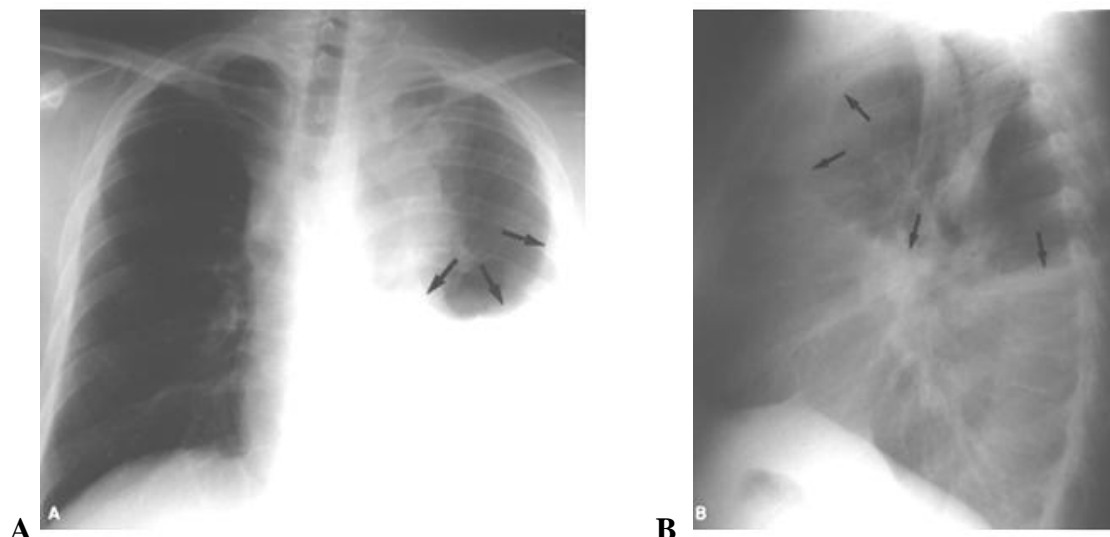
Right pleural effusion on frontal chest radiographs. (A) Posteroanterior and lateral (B) chest radiographs demonstrate the typical homogenous shadow, non-visualization of left hemidiaphragm and costophrenic angle, and meniscoid appearance (arrows) in a patient with a left moderate pleural effusion. There is opacification of the lower right hemithorax with a fluid level, and the mediastinum is pushed to the left side. Note the a laterally placed meniscus, and loss of clarity of the lung and outline of the hemi-diaphragm
